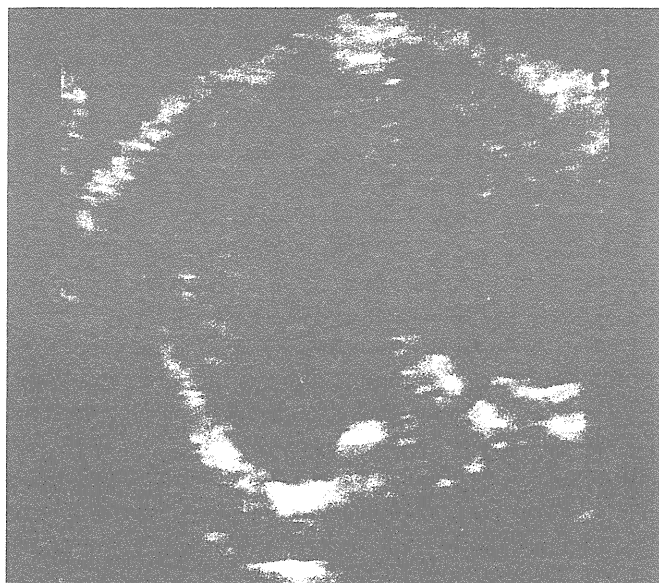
A fetal echocardiographic image of three-vessel and trachea view
